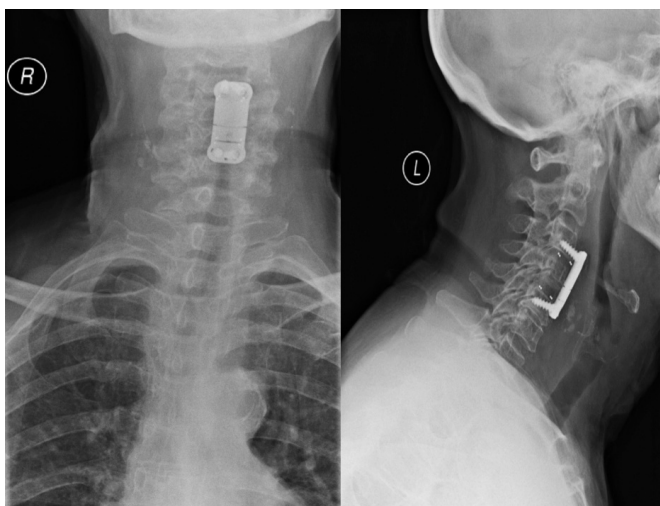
Anteroposterior (left) and lateral (right) postoperative cervical X-rays demonstrating a satisfactory positioning of the cage and plate.
